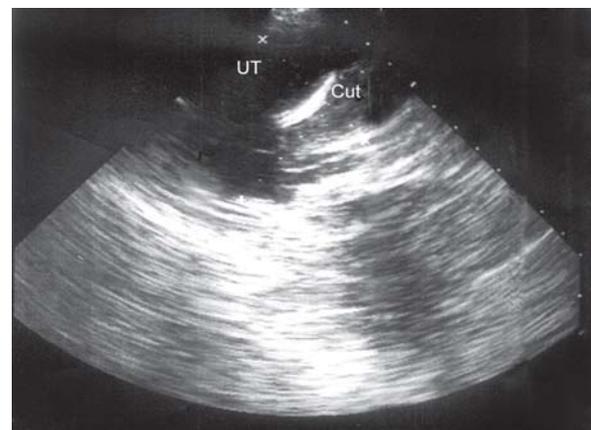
Ultrasonography showing CuT
